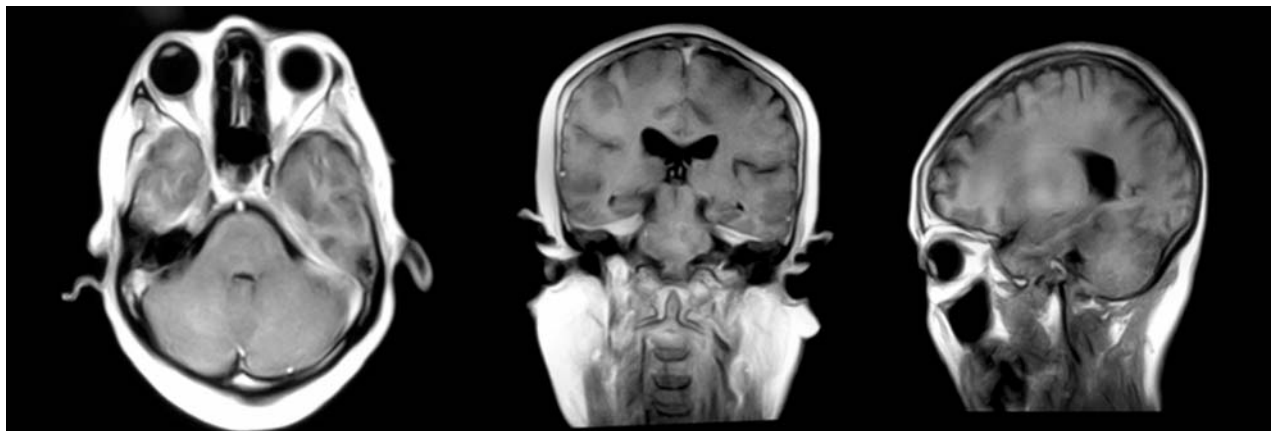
Axial, coronal and sagittal views of a gadolinium-enhanced T1-weighted MRI performed 6 months after having initiated the weekly subcutaneous methotrexate scheme. Important improvement of the dura and brain parenchyma, with respect to basal MRI is evident
